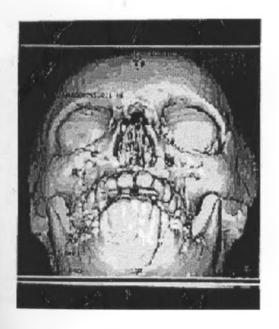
CT image with 3D reconstruction of a 13 year girl following RTA. There's a displaced parasymphyseal fracture.
